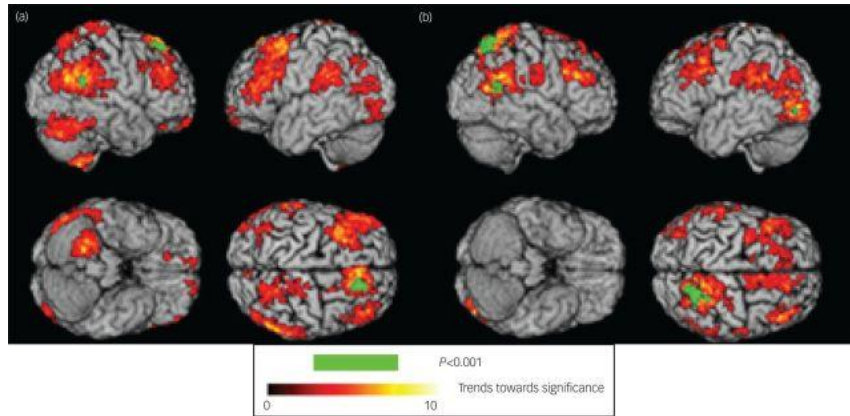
MRI scan measuring patterns of atrophy of (a) grey matter regions and (b) white matter regions in patients with depression relative to healthy controls⁵¹⁶
